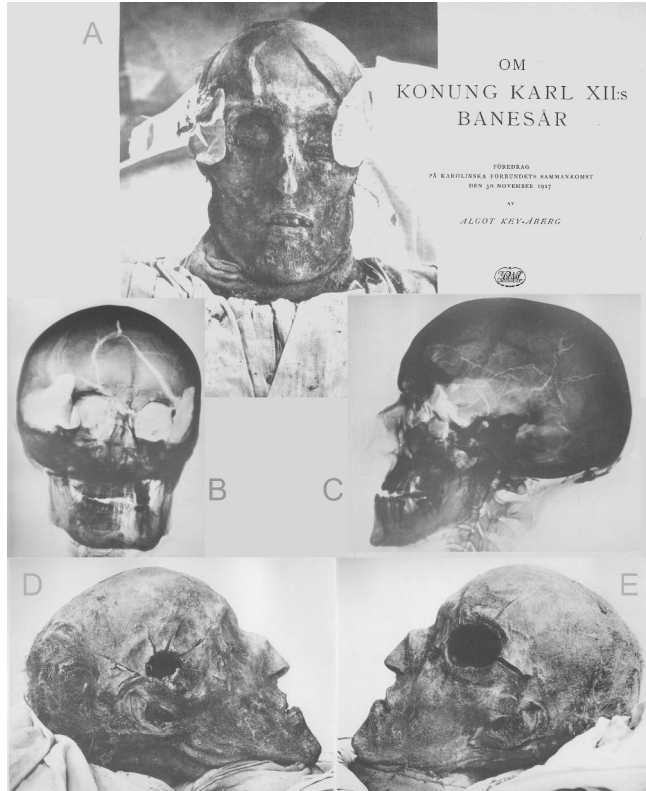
Photographs and radiographs from the 1917 autopsy. A) Frontal view of the King's head with dressings still applied and the cover of the 1917 autopsy book, published in 1918. B) Radiograph of the King's head (frontal view). C) Radiograph of the left lateral portion of the partially reconstructed skull. D) Photographic image of the soft tissue wound on the right temple. E) Photographic image of the soft tissue wound on the left temple. Public domain images. Digitization available at: <https://brf-portalen.se/wp-dragoner/album/k12-banesar/index.html>
